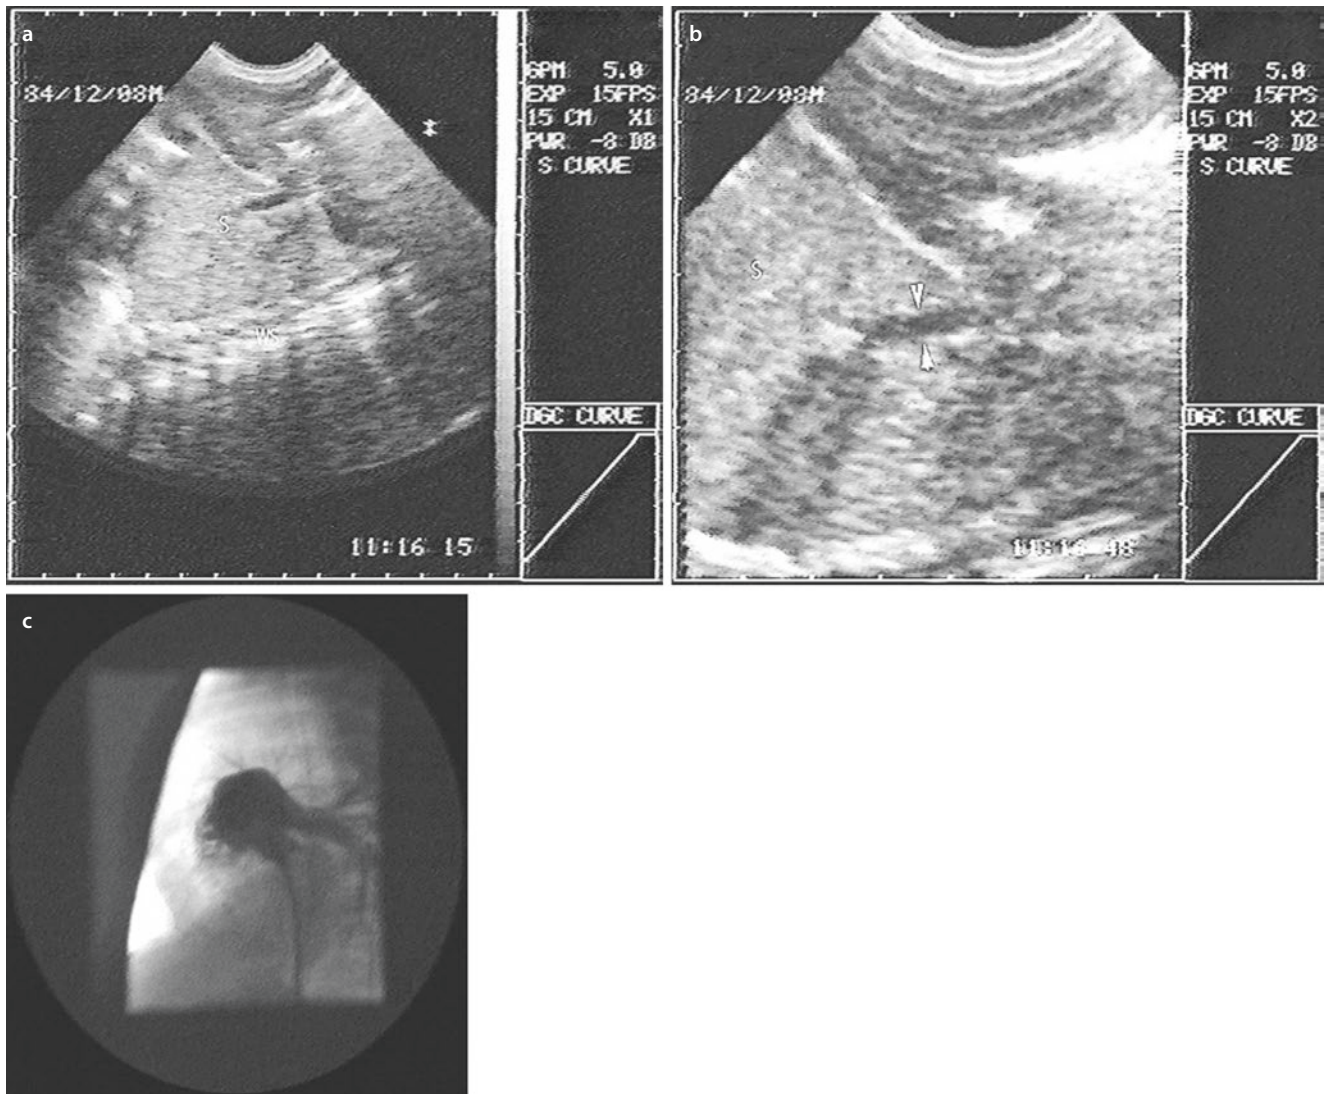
Lung contusion and rib fracture. a On sonography one finds a step in the region of the rib – a sign of fracture. Additionally, free fluid is seen in the chest. Aspiration revealed a hemothorax. b The
